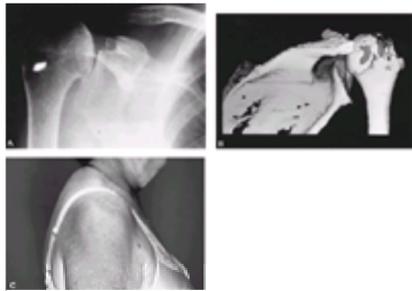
A: The humeral head is anterosuperiorly displaced upon the glenoid after surgical resection of the anterior acromion and coracoacromial ligament. B: A three-dimensional computed tomography reconstruction viewing the glenohumeral joint from a posterior aspect. C: The humeral head is anterior and superior and prominent below the skin.
